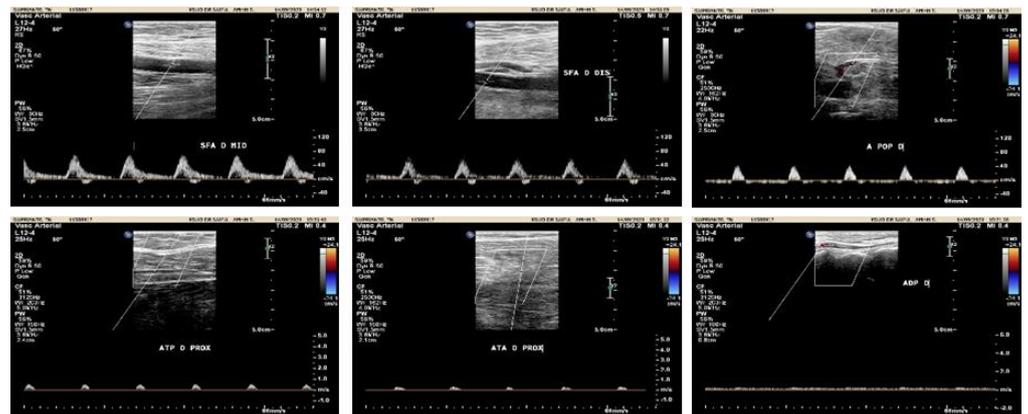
The images above display multiphasic spectral Doppler readings from the right femoral artery to the right popliteal artery. The final three images depict monophasic spectral Doppler readings at the distal arteries.
